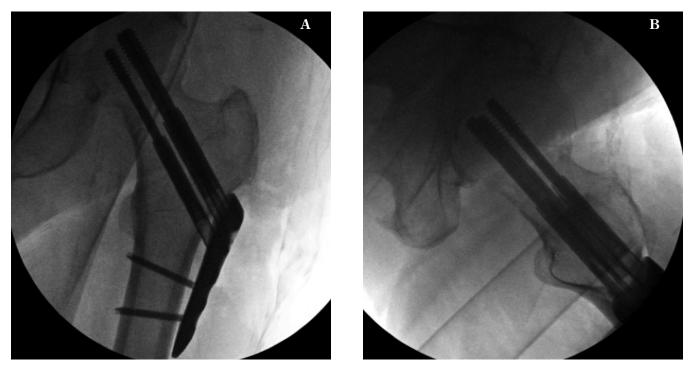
Initial AP (a) and lateral (b) radiographs after closed reduction and internal fixation using the THP.
